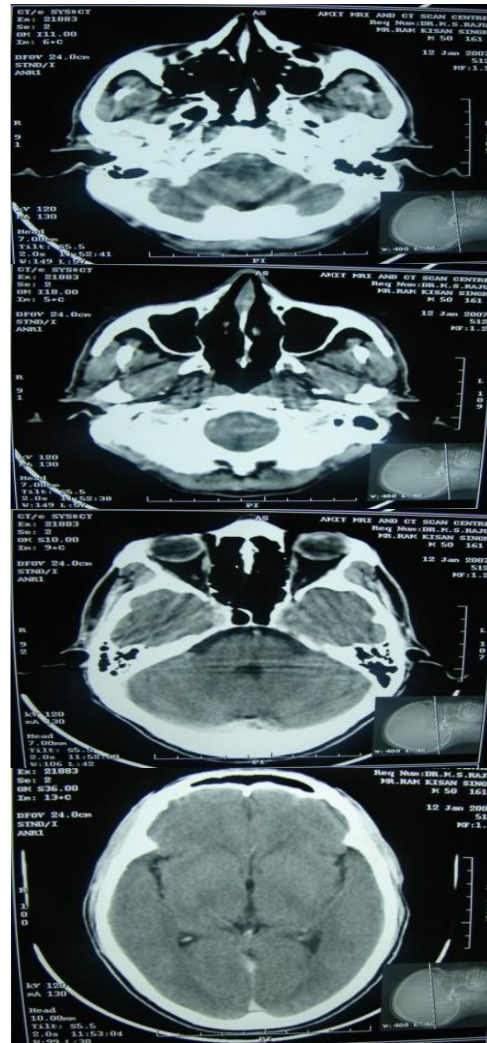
CT imaging results showed no underlying involvement of the bone and no involvement of the orbit or the lymph nodes & intracranial extension
